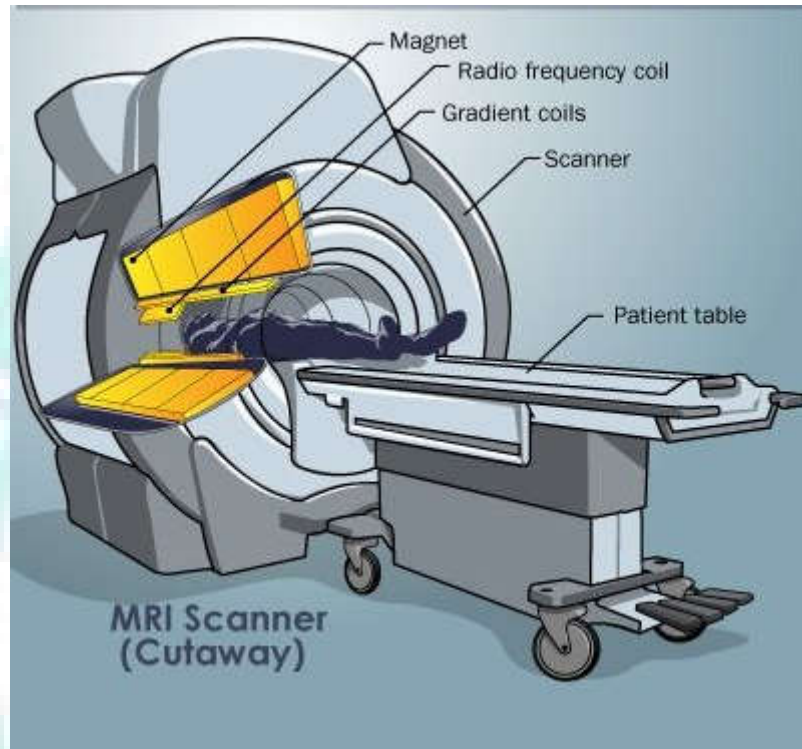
MRI Scanner [10]
